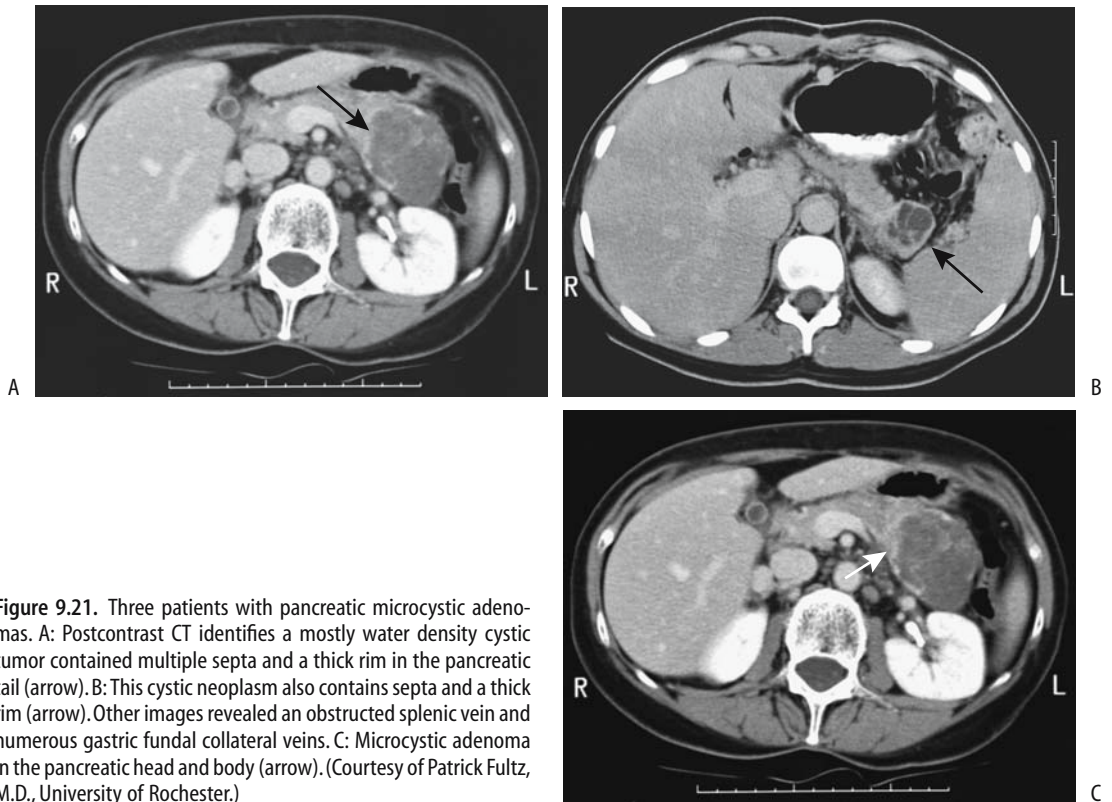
Three patients with pancreatic microcystic adenomas. A: Postcontrast CT identifies a mostly water density cystic tumor contained multiple septa and a thick rim in the pancreatic tail (arrow). B: This cystic neoplasm also contains septa and a thick rim (arrow). Other images revealed an obstructed splenic vein and numerous gastric fundal collateral veins. C: Microcystic adenoma in the pancreatic head and body (arrow). (Courtesy of Patrick Fultz, M.D., University of Rochester.)
